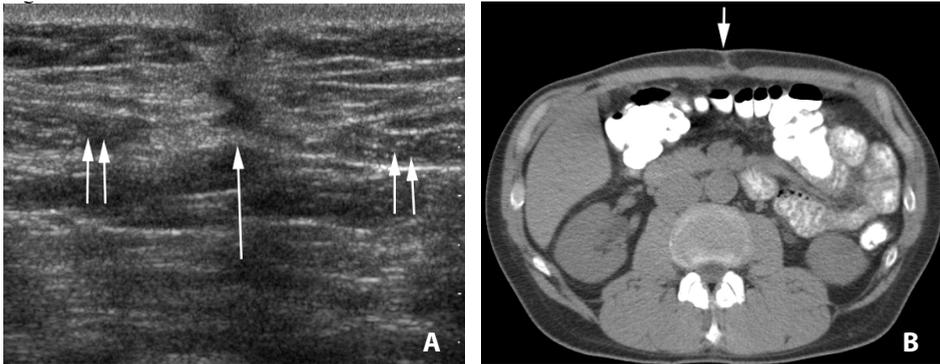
(A) Postoperative sonogram shows the anatomy of the midline abdominal wall after closure, the healing of a median incision, the healed linea alba (one arrow) within the midline, and scar tissue above the fascia of the linea alba. On both sides of the linea alba are the rectus muscles (double arrow) with their anterior and posterior rectus fasciae. (B) Postoperative CT shows the anatomy of the ventral abdominal wall after closure and healing of a median incision, the healed linea alba within the midline, and scar tissue (arrow) above the fascia of the linea alba.
